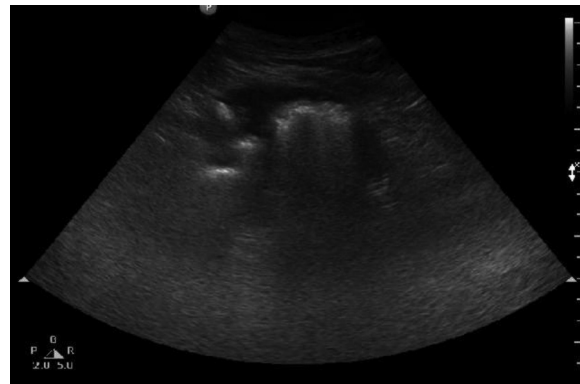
Ultrasound shows intense reflections with dirty acoustic shadows in the left kidney, indicative of the presence of gas.
